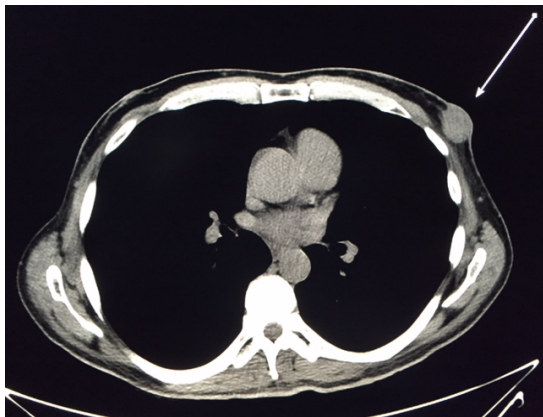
CT scan of the chest showed a mass in the left chest wall with a plane noted between the mass and the pectoralis major muscle.
